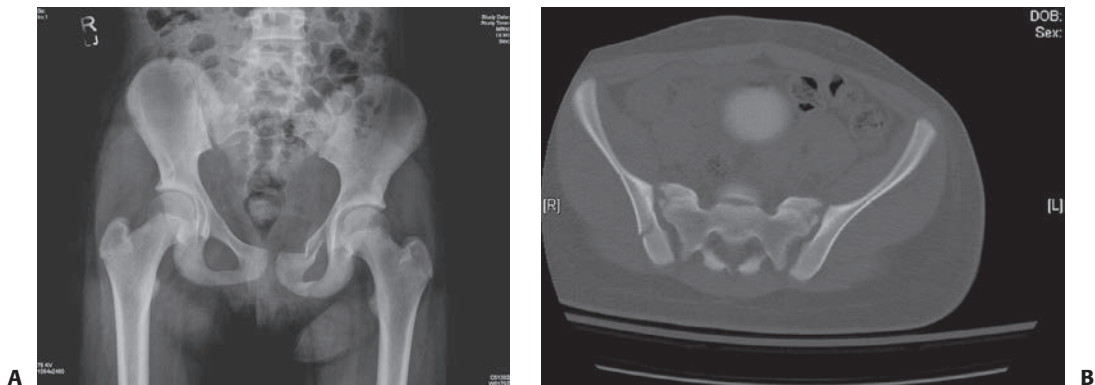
A potentially unstable pelvic fracture with anterior and posterior injury. A: The radiograph shows a left superior and inferior rami fractures. B: The CT scan shows a minimally displaced fracture adjacent to the sacroiliac joint. This is also an example where both CT and plan radiographs can be used to evaluate the injury and help decide on displacement and treatment. This patient was treated nonoperatively with follow-up making sure there was no displacement.
